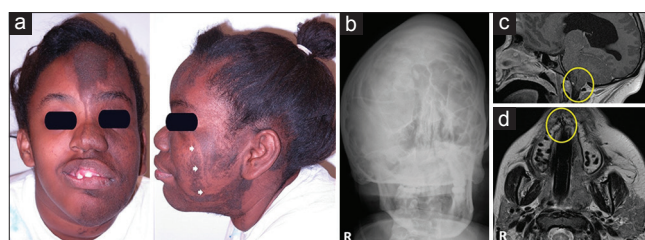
Frontal and left lateral facial view: left hemifacial hypertrophy with raised hyperpigmented patches along the Blaschko's lines indicated by arrows (a), posteroanterior radiograph of the skull: right side compensation (b), computed tomography head images sagittal view: Herniation of cerebellum indicated in yellow circle (c) and axial view: gross left hemifacial hypertrophy and linear defect in maxilla between #7 and #8 area indicated in yellow circle (d)
